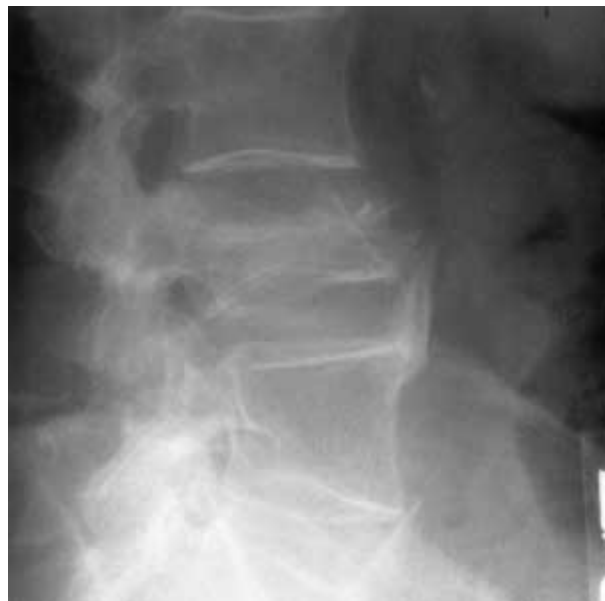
Lateral xray taken one month after xray in figure 1 showing progression of collapse.
